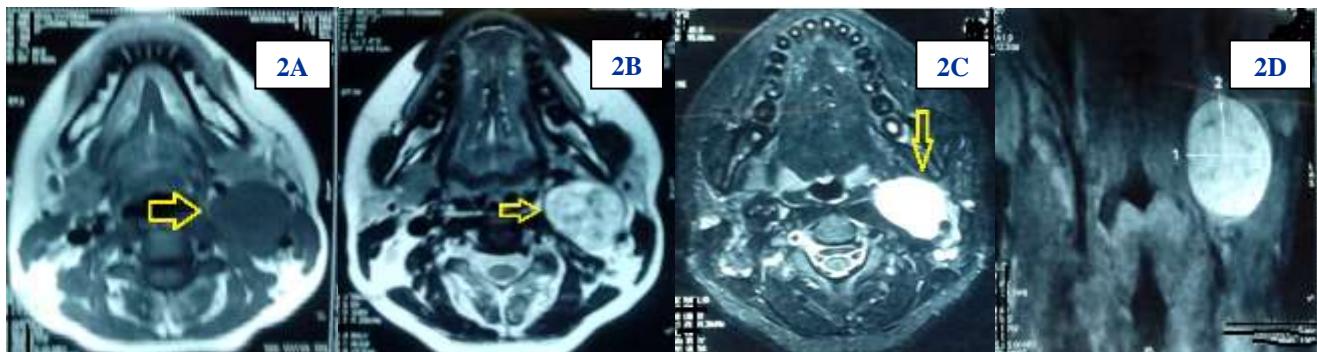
MRI neck: (2A) well marginated 3.4 x 4cm soft tissue mass in the left carotid space causing splaying of carotid vessels which appears hypointense on T1 W images, (2 B) hyperintense on T2W images with salt and pepper appearance (2C, 2D) post contrast enhancement.
